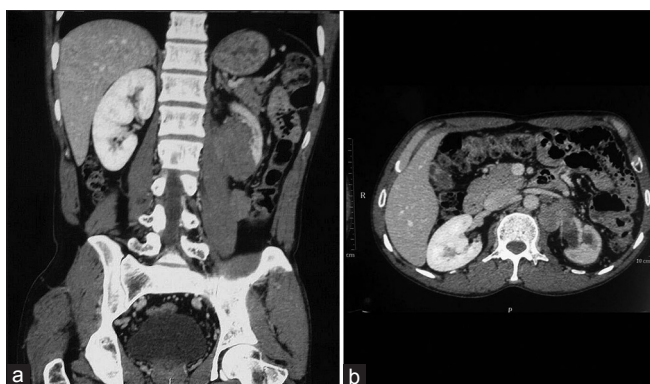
(a) Magnetic resonance imaging showing a large relatively well-defined irregular shape, heterogeneously enhancing mass lesion with delayed filling seen in the perinephric and renal capsular region at the lower pole of the left kidney. (b) Mass is causing complete encasement of renal artery and vein
